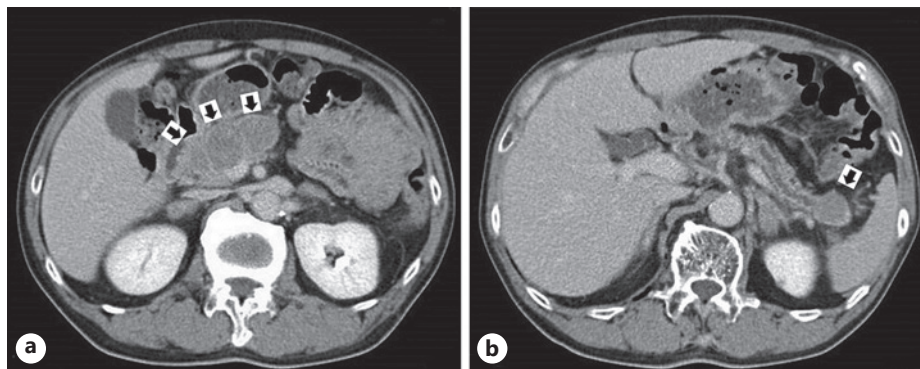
Multiple tumors (arrow) of the head, body (a), and tail (b) of the pancreas on contrast-enhanced CT. CT, computed tomography.
